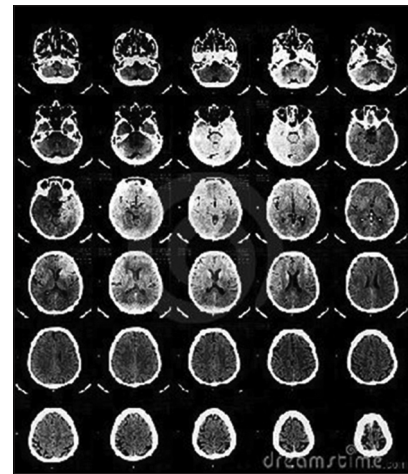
Multidetector computed tomography
